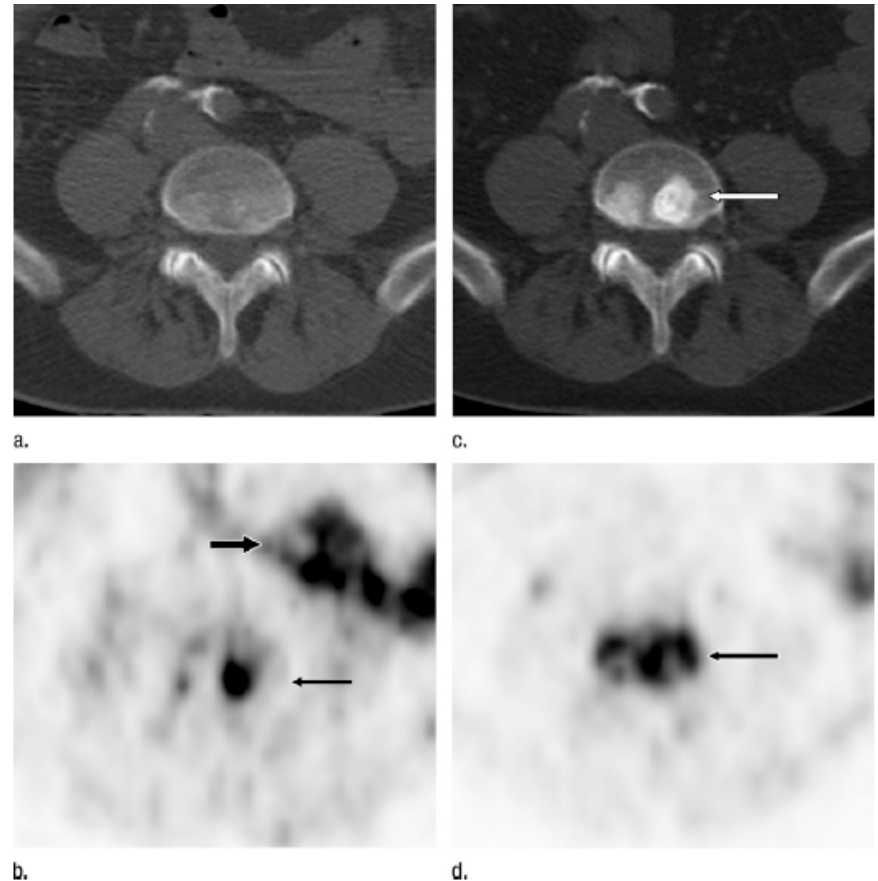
Images obtained in a 73-year-old patient with prostate cancer (Gleason score, seven; PSA level, 5.6 ng/mL [5.6 $\mu\text{g/L}$]) with clinical evidence of disease progression 4 months after radiation therapy and with an increase in PSA level from 0.25 ng/mL [0.25 $\mu\text{g/L}$] to 3.8 ng/mL [3.8 $\mu\text{g/L}$]. (a) The CT portion of an FCH PET/CT image obtained at the L4 vertebra level shows no substantial morphologic change concerning bone metastasis. (b) FCH PET image shows abnormal focal increased tracer uptake (long arrow) at the L4 vertebra level, probably because of bone marrow metastasis, as well as nonspecific bowel tracer uptake (short arrow). (c) The CT portion of an FCH PET/CT image obtained at 6-month follow-up enabled us to confirm the bone metastasis at the L4 vertebra level (arrow). (d) FCH PET image obtained at 6-month follow-up shows hyperactive metastatic bone lesions (arrow) at the L4 vertebra level.
